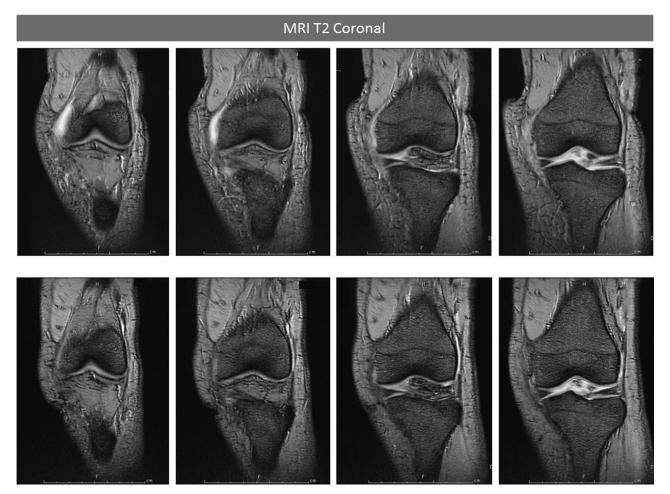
MR images at baseline (upper row) and 2 years after transcatheter arterial embolization (lower row). Coronal T2-weighted gradient-echo MR images show joint effusion at baseline and decreased joint effusion and no evidence of marrow necrosis or other abnormalities at 2 years after embolization.
